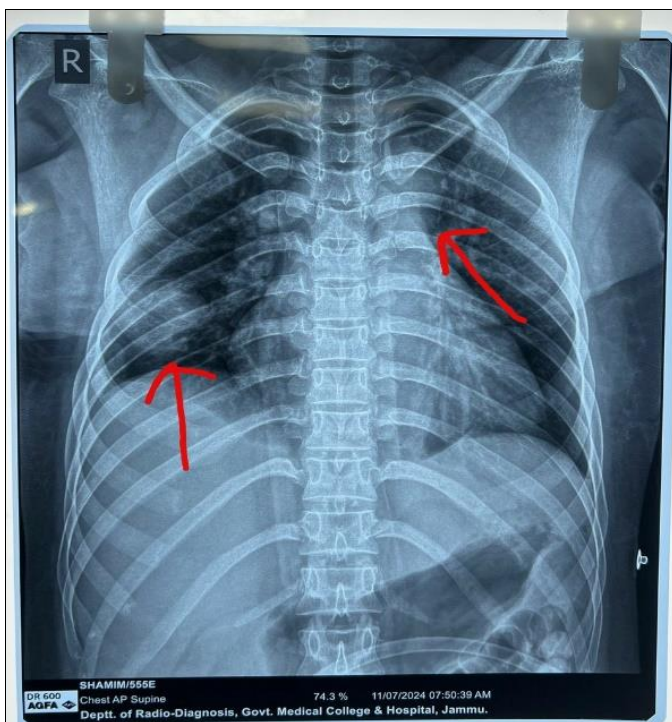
cannon ball lesions on X-ray chest PA view
